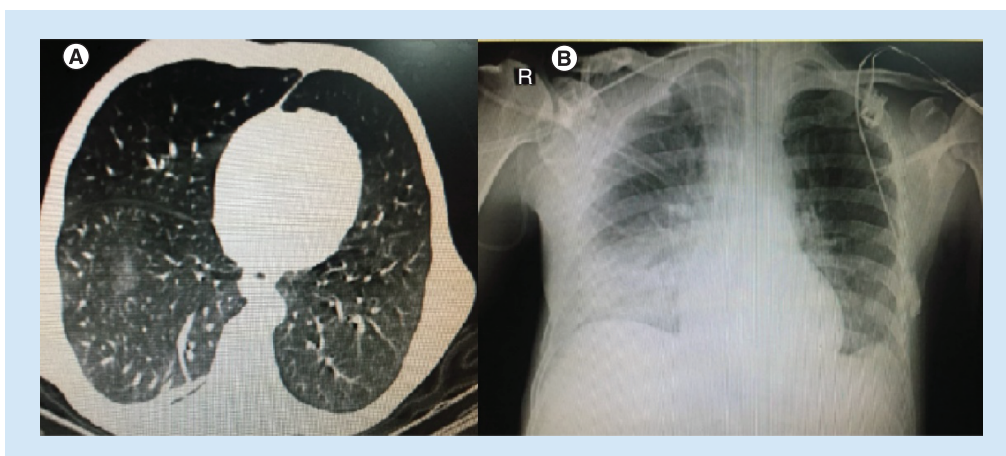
(A) Chest CT scan showing patchy infiltrations suggestive of COVID-19. (B) CXR on the ninth day of hospitalization.
